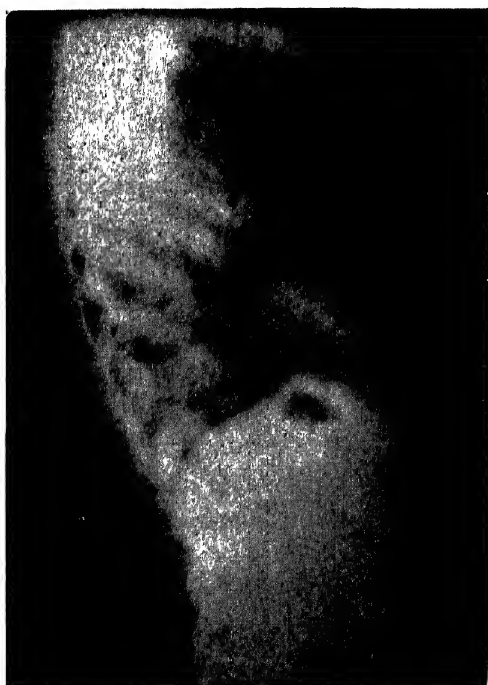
Lateral roentgenogram of the chest of the patient taken after diagnostic thoracentesis which revealed chocolate sauce pus. The fluid level may be clearly observed in the right pleural cavity. (A. Ochsner and M. DeBakey : Surgery.)
